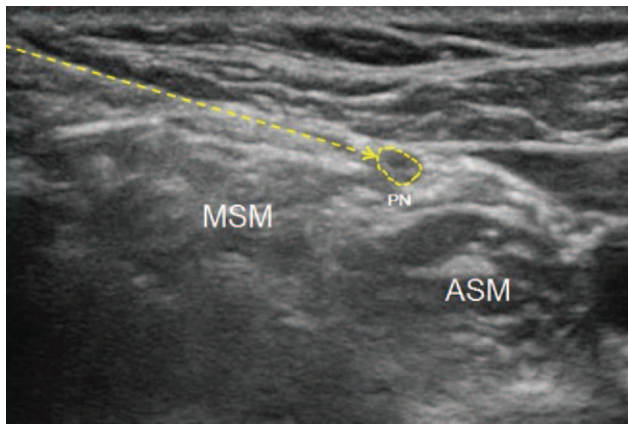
Ultrasound-guided PRF image of phrenic nerve. The yellow dotted circle indicates the phrenic nerve; the yellow arrow indicates the needle pathway. ASM: Anterior scalene muscle; MSM: Middle scalene muscle; PN: Phrenic nerve; PRF: Pulsed radiofrequency.
